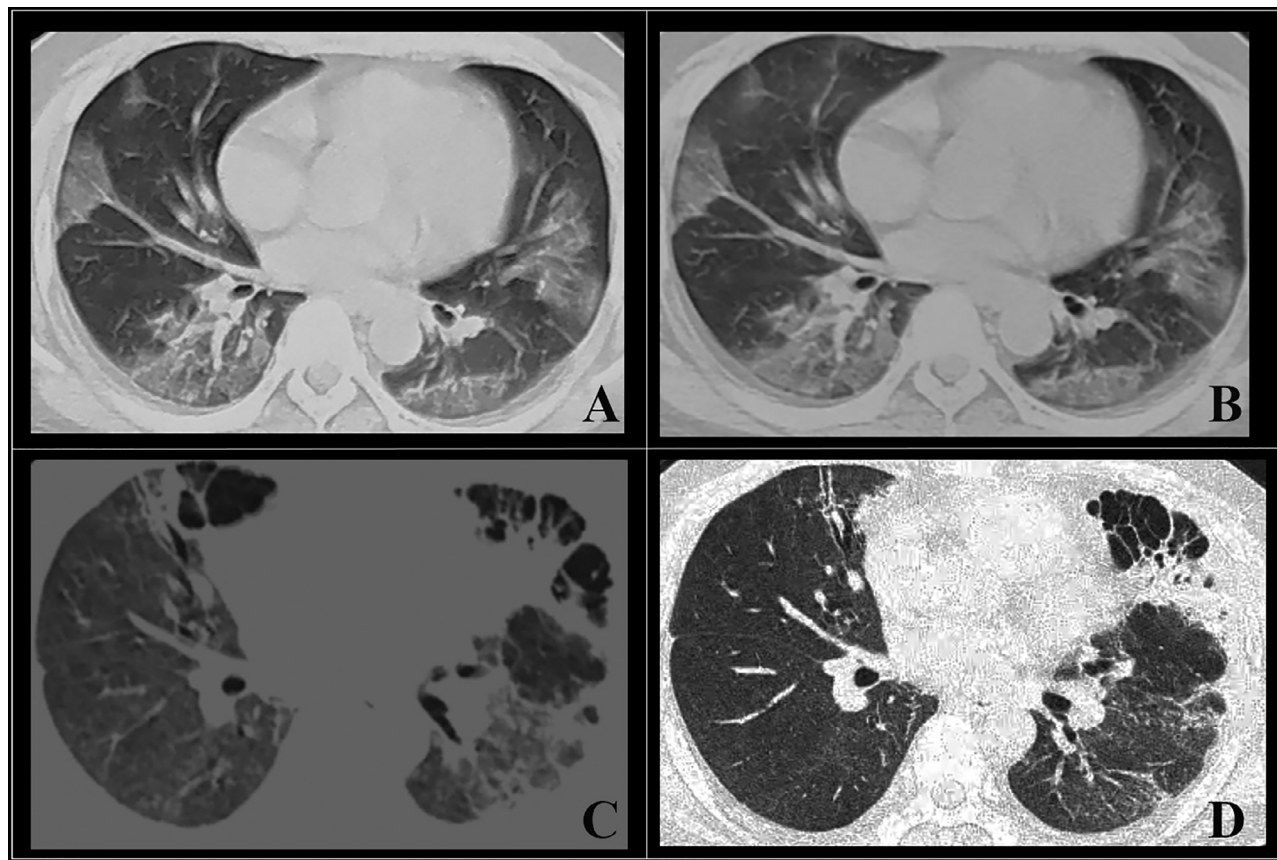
Chest CT images in a 35-year-old man with COVID-19. A. Initial chest CT image on admission showed multiple peripheral GGOs and patchy consolidations in both lungs. (B–D) Follow-up CT images obtained on day 12, 24, and 32, showed localized emphysema and pulmonary bullae in subpleural area in bilateral upper lobes, where no previous lesions were present.
